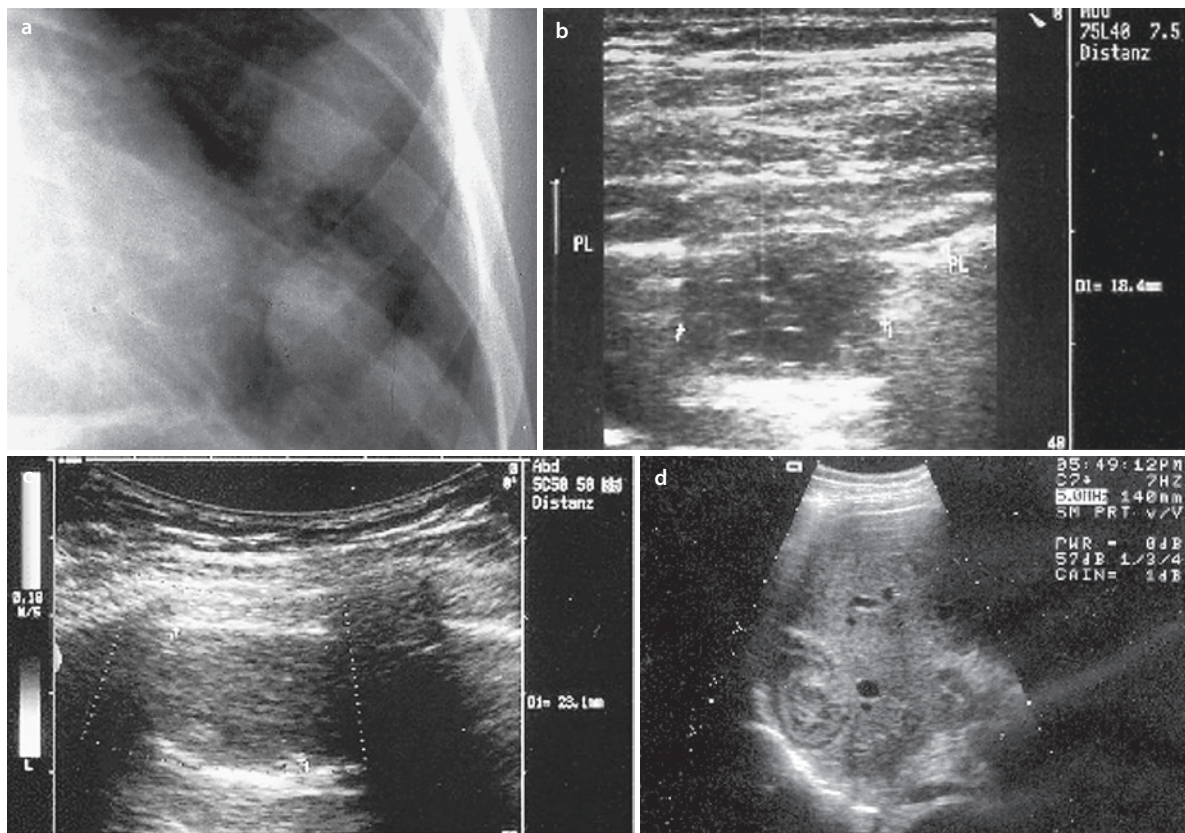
Echinococcus cysticus*. A 28-year-old man with pulmonary echinococcosis in his medical history. The patient was admitted to the hospital because of fever, cough, and marked dyspnea. a, b The X-ray shows multiple round lesions in the lung and pneumonic infiltrates. c Sonography revealed the round lesions extending to the surface of the lung. Thick-walled cysts (crosses) with internal secondary cysts showing
